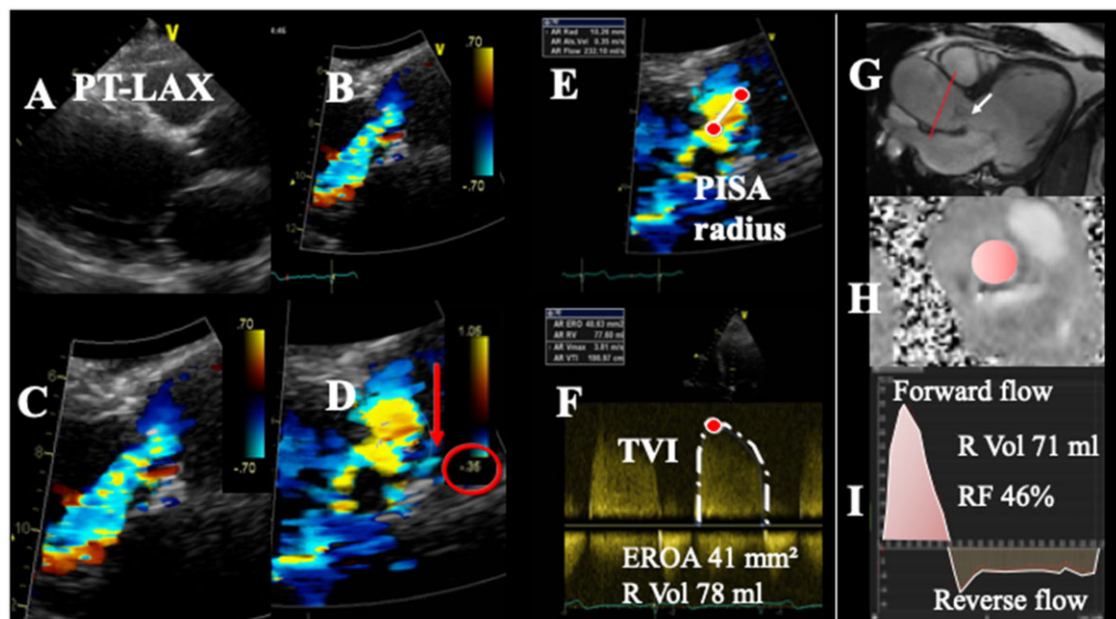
Quantitative assessment of AR severity using the PISA method (A–F) and the CMR phase-contrast method (G–I). Stepwise analysis of AR. (A) Parasternal long-axis view (PT-LAX). (B) Colour-flow display. (C) Zoom of the selected zone. (D) Downward shift of zero baseline to obtain a hemispheric PISA. (E) Measure of the PISA radius using the first aliasing. (F) Continuous wave Doppler of AR jet allowing calculation of the effective regurgitant orifice area (EROA) and regurgitant volume (R Vol). CMR evaluation of AR by direct method (G–I). (G) Aortic root positioning (white arrow: extent of the signal loss on cine); (H) phase-contrast velocity mapping at the aortic root level; and (I) flow-time curves computing forward and reverse or backward flows. The reverse flow represents the directly measured volume of AR. TVI, time-velocity integral.
